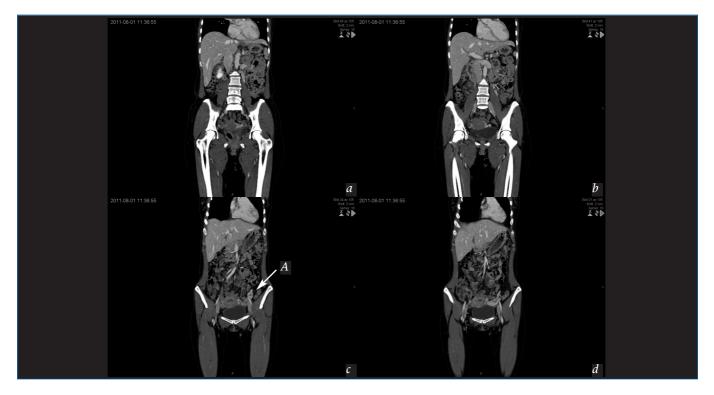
Computed tomography (a,b,c) shows incompetent left ovarian vein (A) filling dilated ovarian plexus (d).
